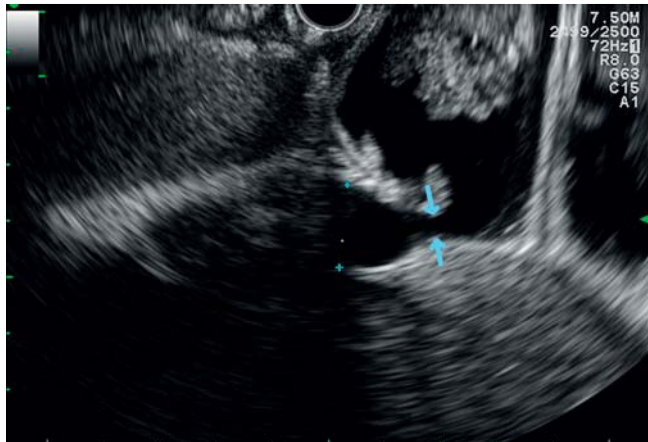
Endoscopic ultrasound (EUS) with transducer in the duodenal bulb in a 70-year-old man having recurrent episodes of biliary sepsis (patient 2). Note the dilated intrahepatic bile duct (15 mm, left between crosses) and efferent jejunal loop (33 mm, right) with open anastomosis (arrows).
